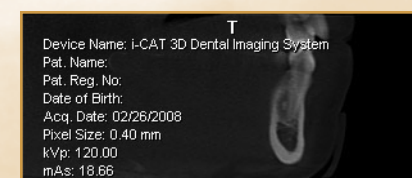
CBCT cross-sectional image in #21 area.
